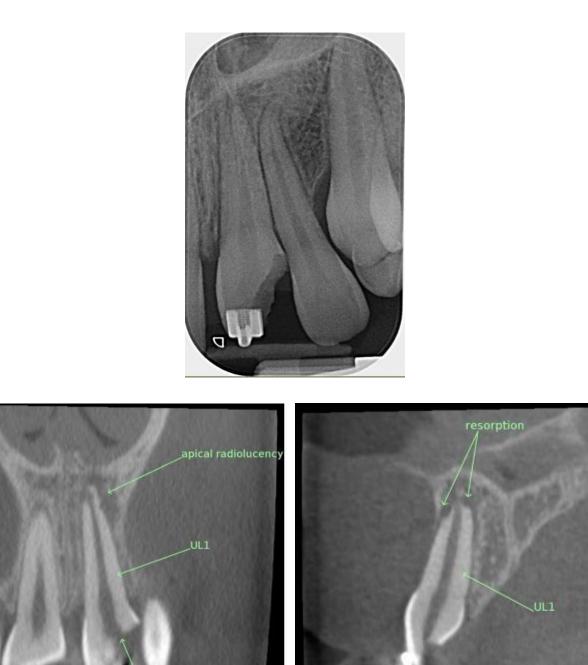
A periapical radiograph of the UL1 and images from the CBCT scan of the UL1 showing external inflammatory root resorption and apical pathology
